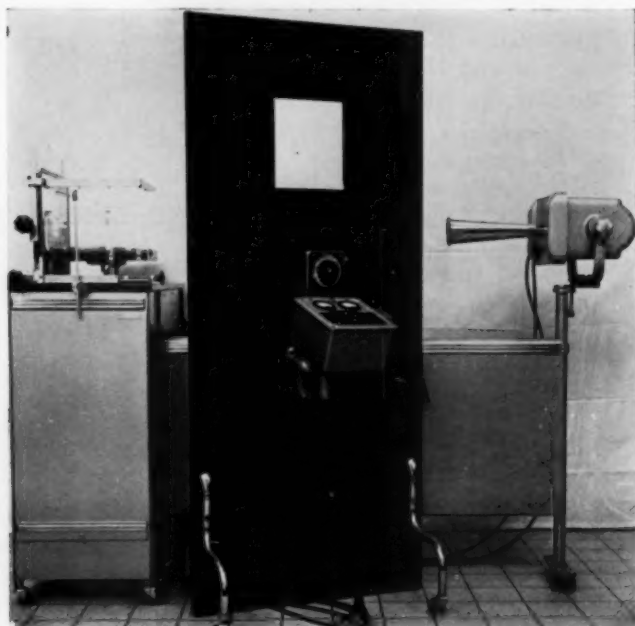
Specially designed cephalometer. The X-ray tube for the frontal film is concealed within the cabinet beneath the head holding device.
